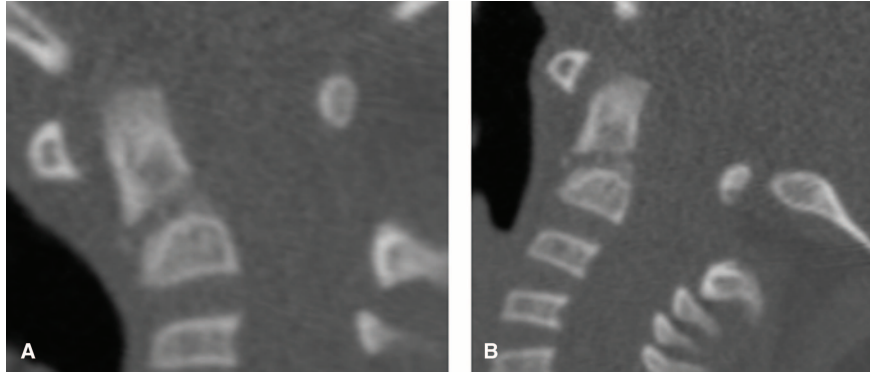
Computed tomographic scan of the cervical spine showing kyphotic angulation (28.6°) and anterior displacement (2 mm) of the odontoid at 1 month postinjury. Kyphotic angulation was defined as the angle between a tangent line drawn along the posterior aspect of the fractured odontoid fragment and the posterior aspect of the C2 body. The degree of (sagittal) displacement was defined as the distance between a tangent line along the anterior aspect of the odontoid fragment and the anterior aspect of the C2 body.⁸ Both parameters were measured using PACS EasyVision Systems (Philips B.V., Best, the Netherlands).
